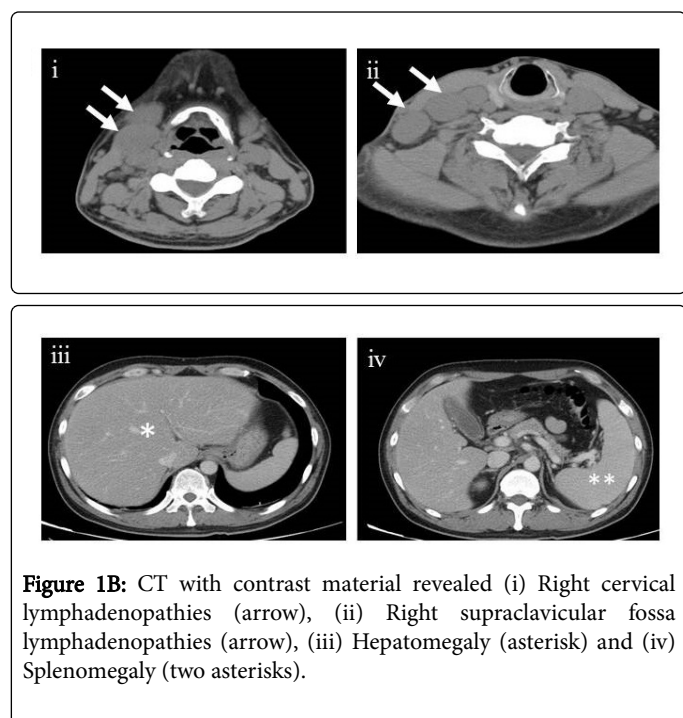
CT with contrast material revealed (i) Right cervical lymphadenopathies (arrow), (ii) Right supraclavicular fossa lymphadenopathies (arrow), (iii) Hepatomegaly (asterisk) and (iv) Splenomegaly (two asterisks).
